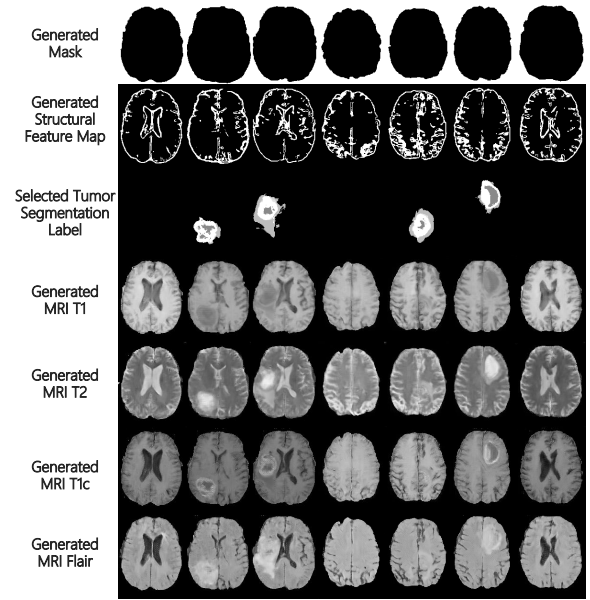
Multimodal MRI generated from the random structural feature map and lesion label.
